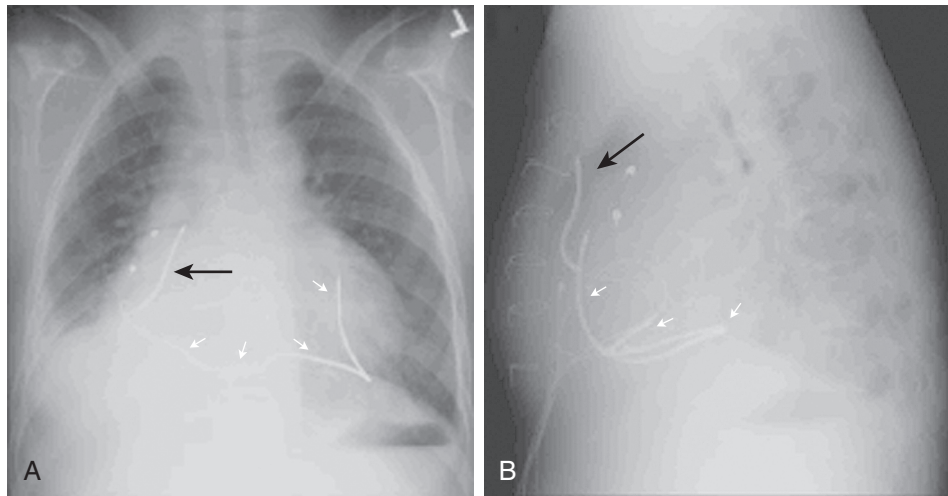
■ Chest radiograph of an epicardial implantable cardioverter-defibrillator system in an adult in whom a Kawashima-type Fontan operation was performed for heterotaxy and double-outlet right ventricle. A, Posteroanterior projection. B, Lateral projection. Defibrillation was obtained via two coils placed in the pericardial space. A short (5-cm) coil is present (*large arrow*), typically used in the superior vena cava and now placed in the pericardial space along the right side of the spine. The second long (25-cm) coil (*small arrows*), normally implanted subcutaneously, lies under the heart and then ascends to the right of the spine.
